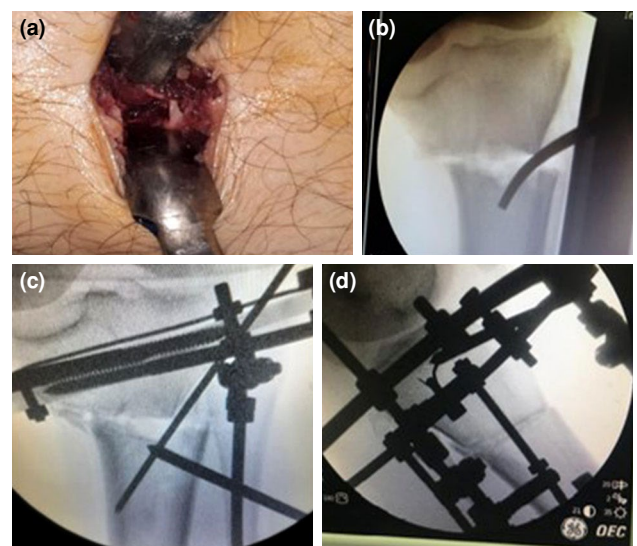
(a) Fibular osteotomy. (b) Lateral translation of the distal segment to correct the mechanical axis deviation. (c) Fixation of the osteotomy after translation. (d) Intraoperative X-ray showing the position of the motor along the sagittal plane of the tibia.
